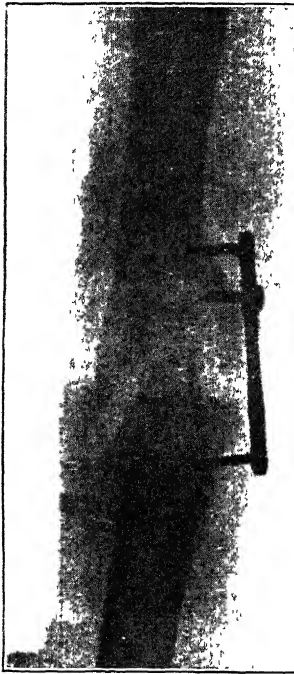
Simple fracture of middle of shaft of right humerus. Radiograph of fracture before final operation, with bone plate still *in situ*.
